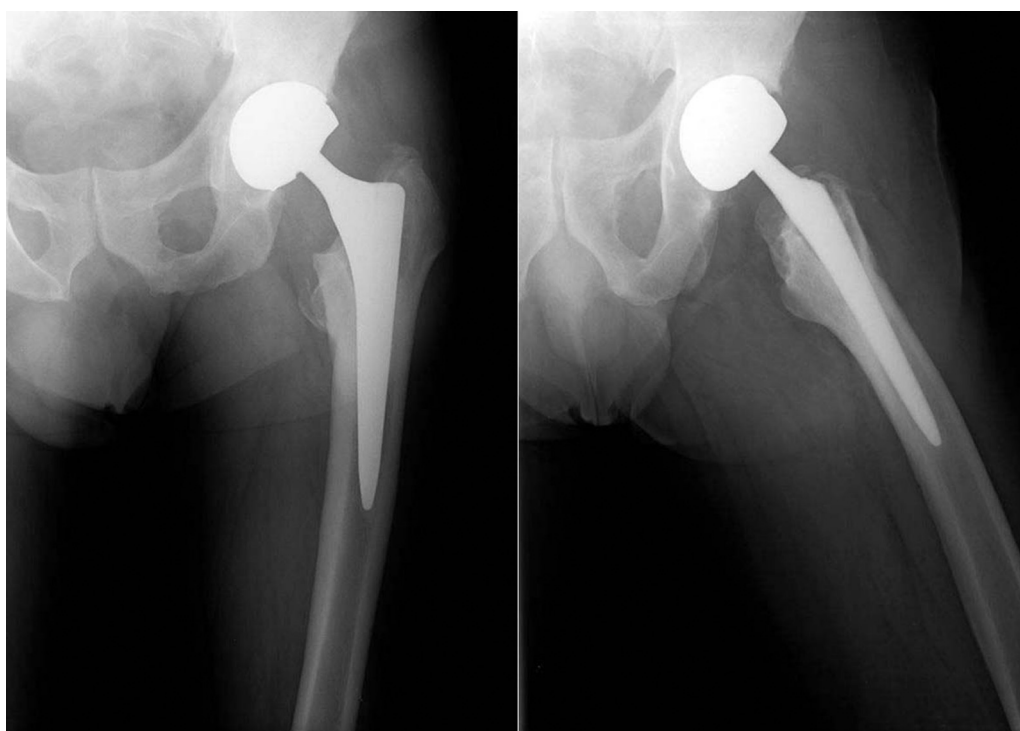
Osteolysis of the greater trochanter at 2 year X-ray follow-up.
